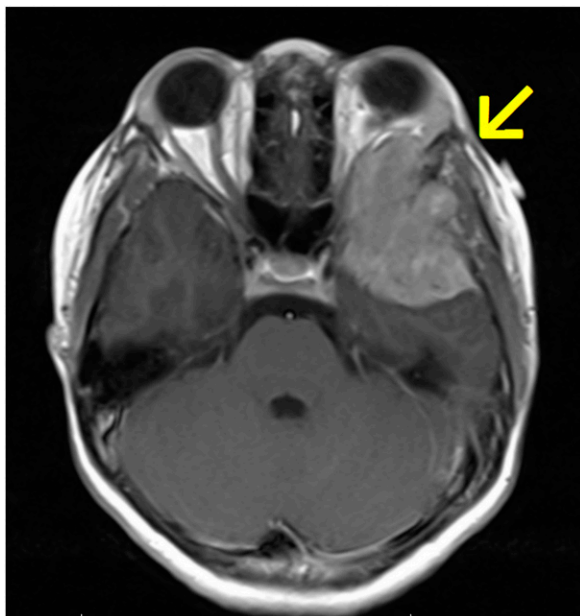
Magnetic resonance image demonstrating a soft tissue mass (yellow arrow) centered in the left sphenoid bone.
